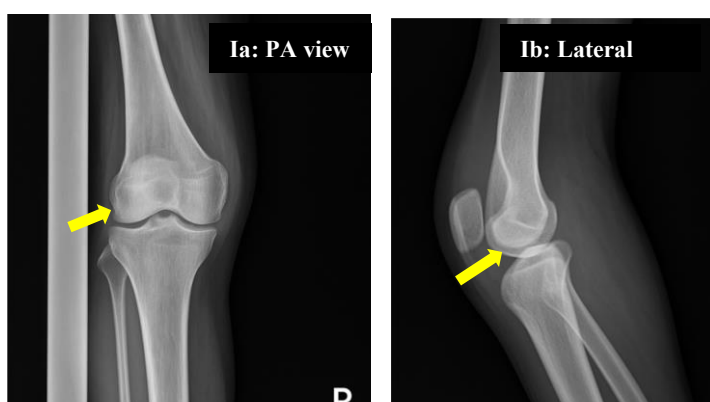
X-ray of right knee joint
